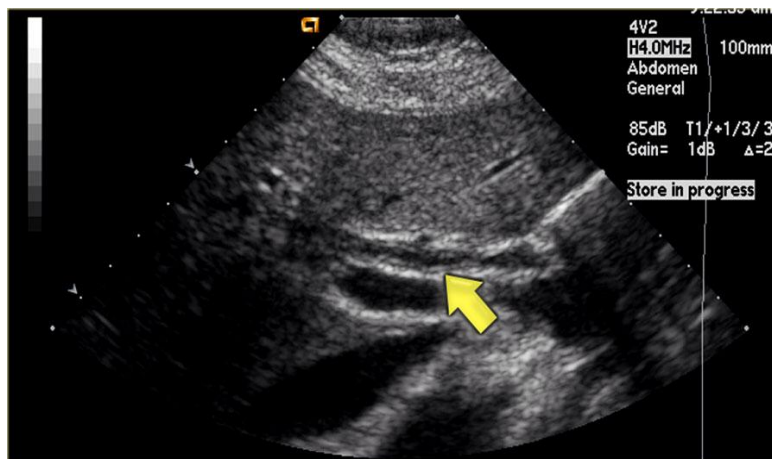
Ultrasound Findings in PSC (thickening of bile duct wall)³⁶
